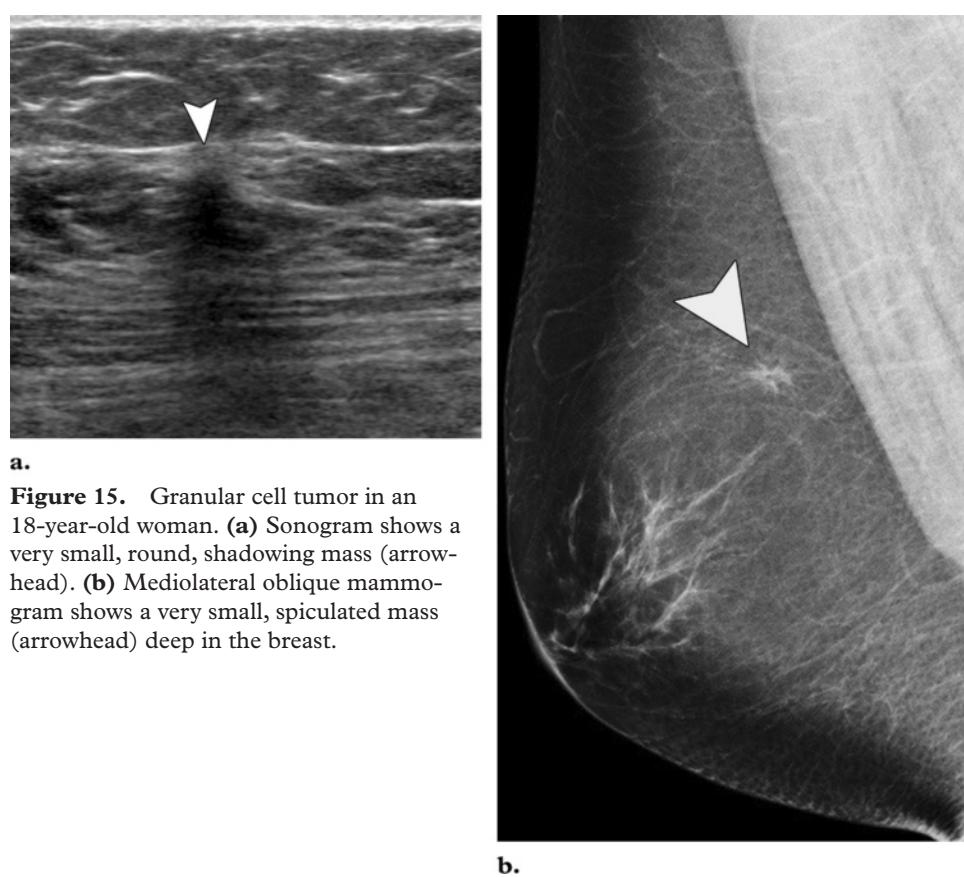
Granular cell tumor in an 18-year-old woman. (a) Sonogram shows a very small, round, shadowing mass (arrowhead). (b) Mediolateral oblique mammogram shows a very small, spiculated mass (arrowhead) deep in the breast.
